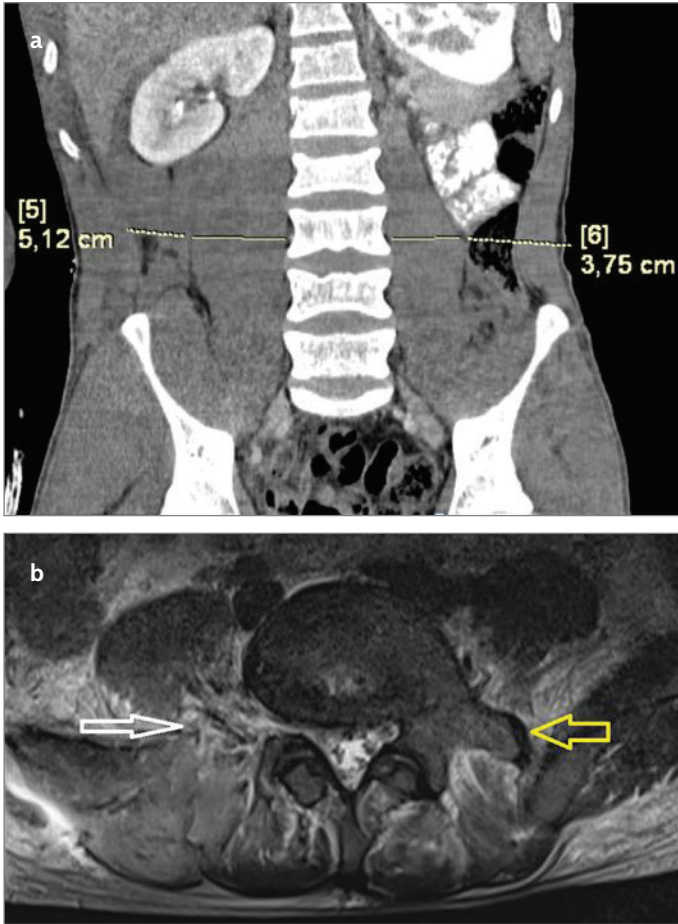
a, b. (a) CT image: 2 months after the trauma; right IPH disappeared, borders of the right ilio-psoas muscle were regularly seen (b) Magnetic resonance imaging; 2 months after the trauma: Both iliopsoas muscles are of normal size and shape. White arrow indicate the absence of the right transverse process, yellow arrow shows the normal size and shape of the left transverse process
